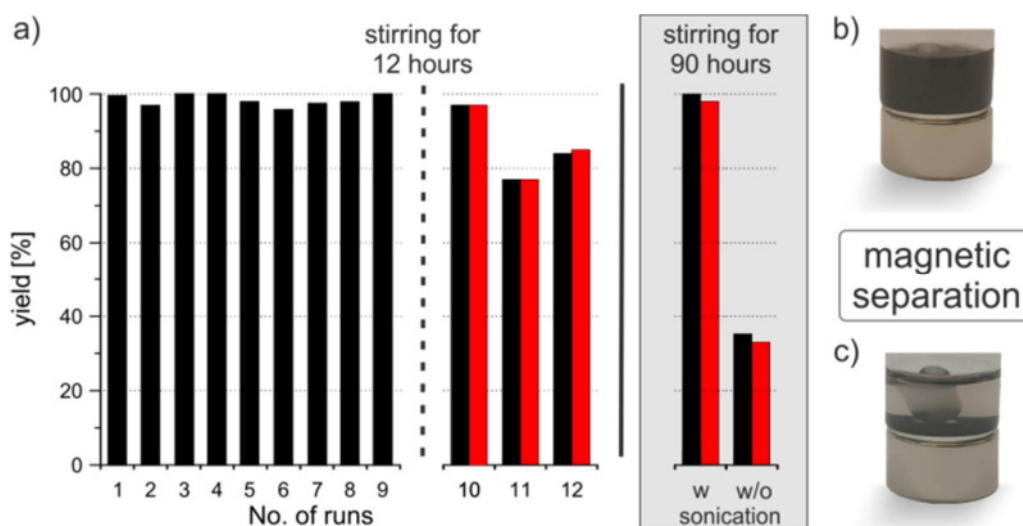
a) Consecutive hydrogenation runs of styrene (0.5 mmol) using the same catalyst particles (5 mol%) and regeneration of catalyst activity by ultrasonication (box); yields (black), conversions (red). b) Suspension of the hydrogenation reaction of styrene with 5 mol% Co-NP. c) Catalyst separation by an external magnet (after 1 min).
